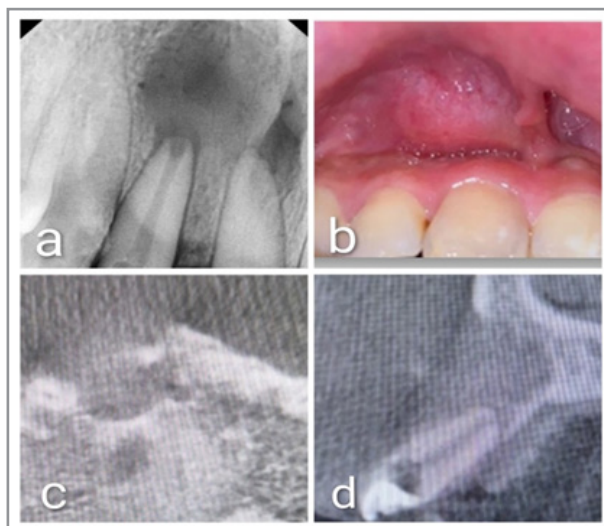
a) Radiograph of 11, 12 regions which reveal radiolucency involving periapical region b) Picture showing swelling in labial vestibule region c) Cbct image axial view showing bone loss d) Cbct image Saggital view showing bone loss involving labial plate
